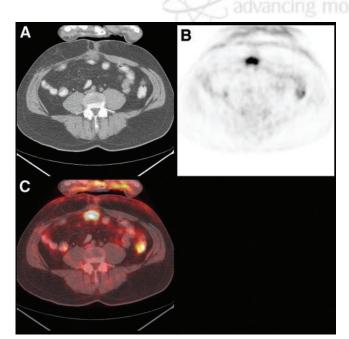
Recurrent colorectal cancer. (B) Intense focal uptake was seen in anterior abdomen on PET. It was unclear whether this was in bowel or peritoneum. CT (A) and fused image (C) showed bowel to be opacified by oral contrast and that focus of intense activity was just anterior to bowel. Focus was peritoneal metastasis and not atypical normal bowel uptake. Scar just anterior to focal uptake was normal in appearance and intensity of uptake. (Courtesy of C. Cohade, MD).
